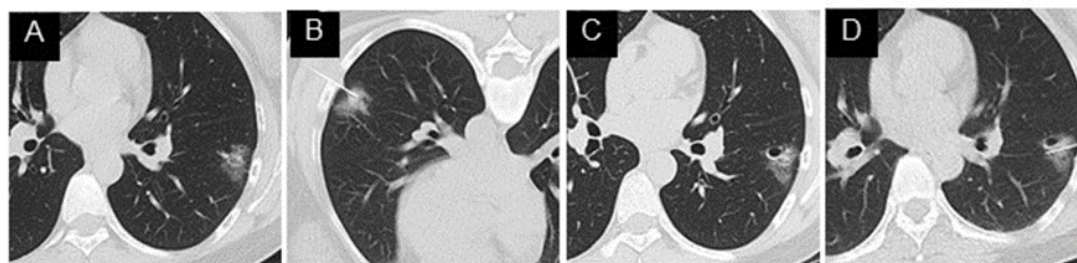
A 47-year-old female was incidentally found to have a focal patchy opacity on a check-up CXR (not shown). (A) Axial CT chest showed a focal consolidation with peripheral ground glass opacity at the left lower lobe. (B) CT chest during the TTNB procedure in prone position showed the biopsy needle in the target lesion. The pathological result from CNB was mild chronic inflammation and no malignancy. (C) Follow-up CT chest 16 months later showed an unchanged size, but a slightly increased density. (D) CT chest during indocyanine green (ICG) localization showed the needle in the lesion. The pathological result from left lower lobectomy was adenocarcinoma of the lung.
